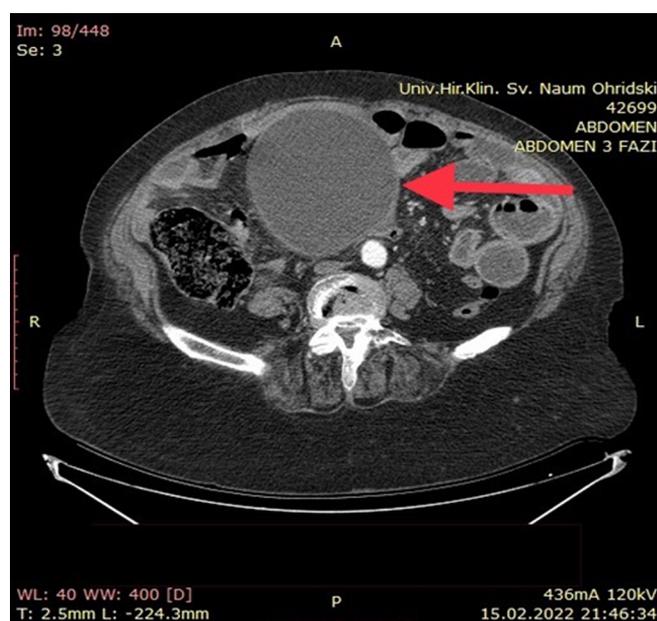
Axial CT scan of the abdomen showing the cystic tumor (arrow)
